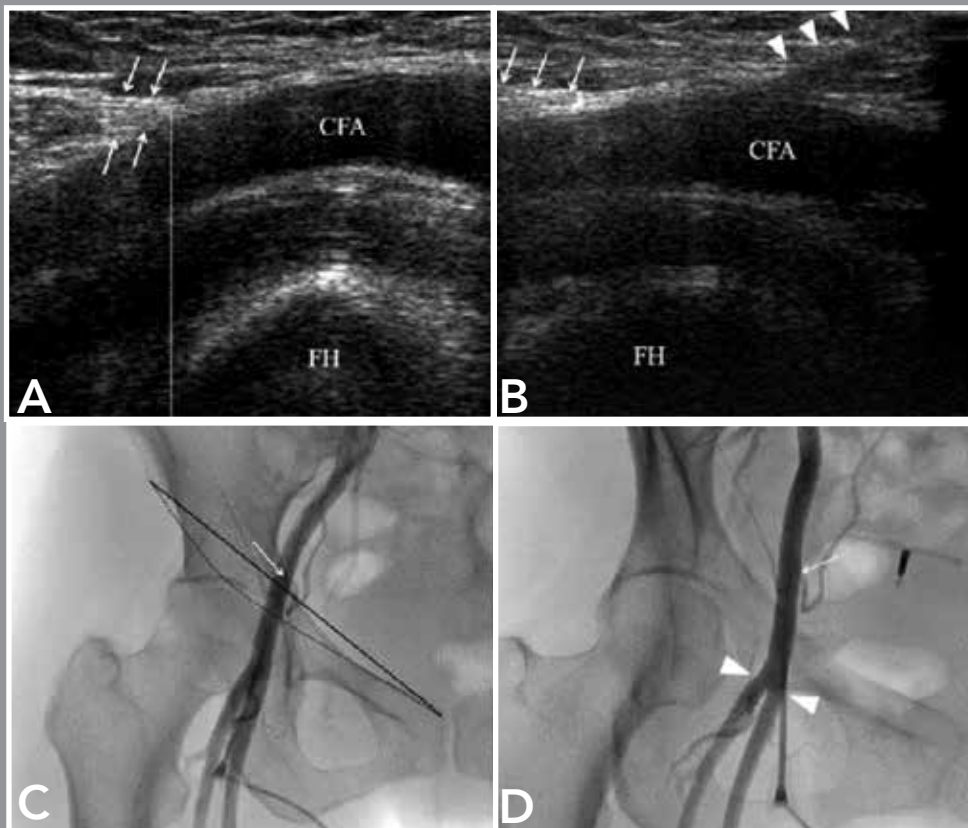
Ultrasound and Femoral Angiogram Images
